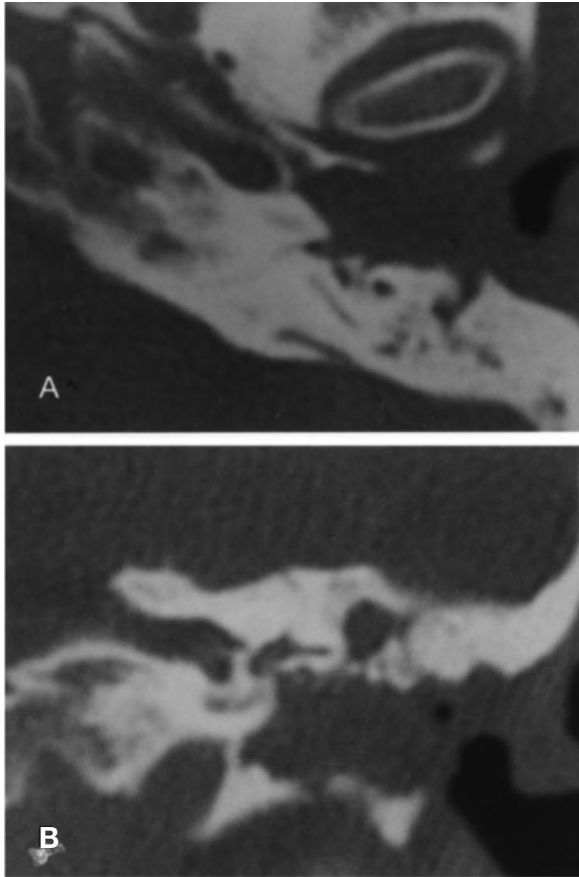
Agnesis of the right external auditory canal, coronal computed tomographic sections. *A*, The external auditory canal is absent and the mandibular condyle is displaced posteriorly and lies lateral to the atretic plate. The middle ear cavity is aerated and normal in size, but the head of the malleus and body of the incus appear malformed and fused. *B*, The mastoid is well pneumatized and clear. The vertical segment of the facial canal is rotated slightly outward.
